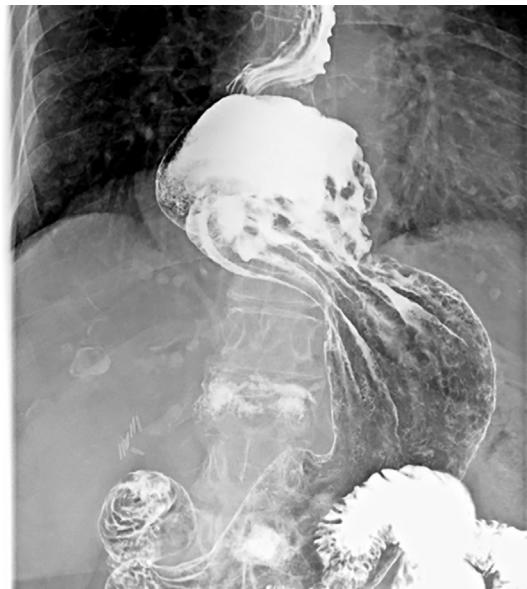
Barium radiograph of a paraesophageal hernia in an elderly patients with dysphagia.
